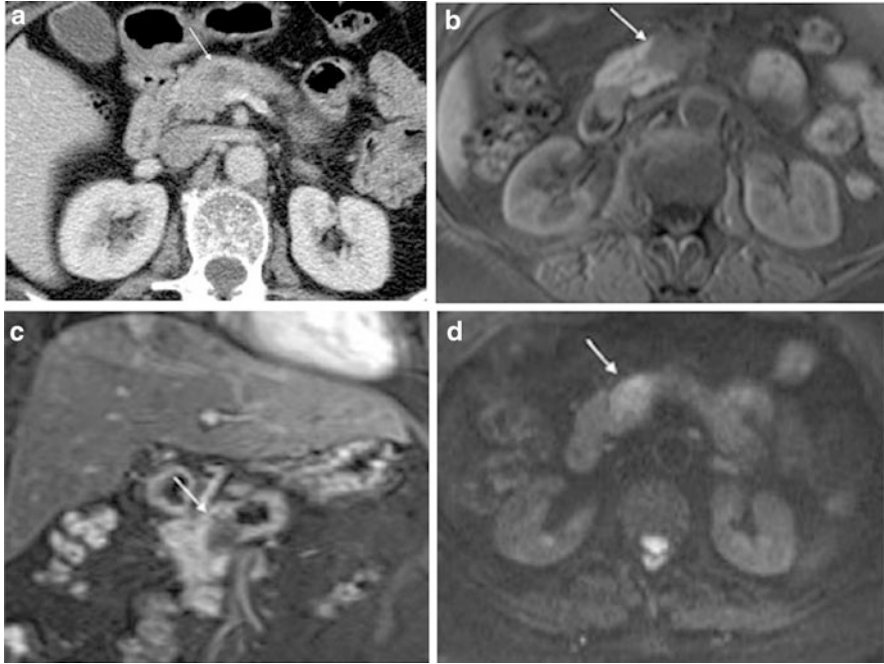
CT and MR findings of a pancreatic adenocarcinoma in the neck of pancreas. (a) Axial contrast enhanced CT demonstrating a nonspecific hypo/ iso-dense swelling of the head of pancreas with no defined mass (*white arrow*). (b) Axial T1w noncontrast image demonstrating a hypointense mass (*white arrow*) within the pancreas. (c) Post-contrast coronal T1w fat saturated image demonstrating a hypoenhancing mass with a normally enhancing pancreatic head. (d) Diffusion weighted images at a high “b” value demonstrating restricted diffusion (*white arrow*) (Images courtesy of Dr. R. Albazaz, Leeds Teaching Hospital NHS trust)
